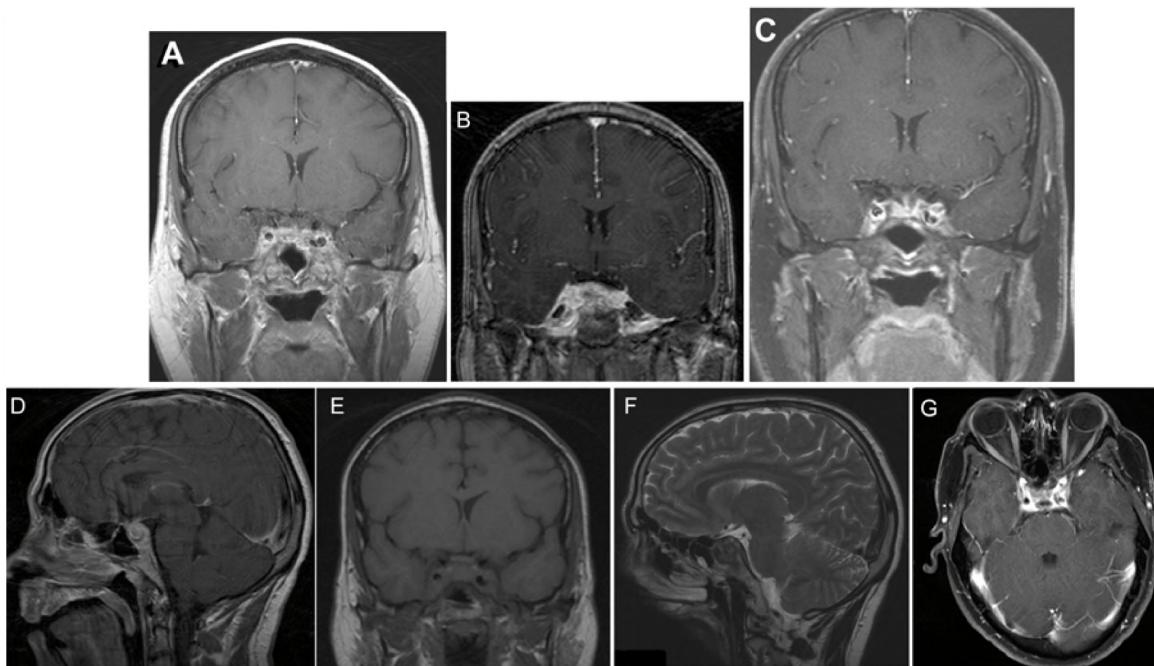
Magnetic resonance images demonstrating extensive meningeal thickening and enhancement primarily involving the bilateral cavernous sinuses, superior clivus region, and distal petrous internal carotid artery canals. The lesion is enhancing of post-gadolinium T1-weighted sequences (A-D), isointense on T1-weighted sequences without gadolinium (E), and hypointense on T2-weighted sequences (F). (G) Post-gadolinium T1-weighted MRI one year after biopsy, with near complete resolution of the lesion.
